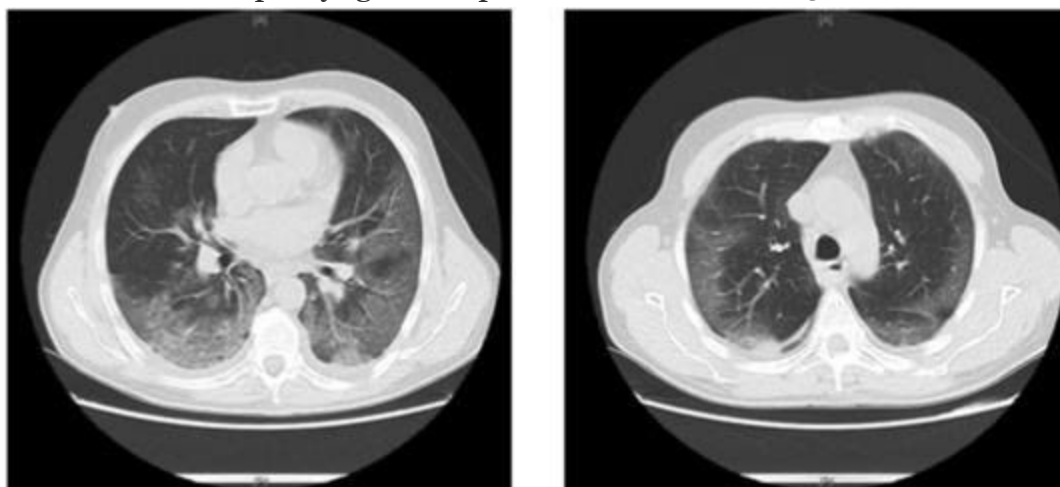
Chest CT-scan showing bilateral pulmonary infiltrates.
